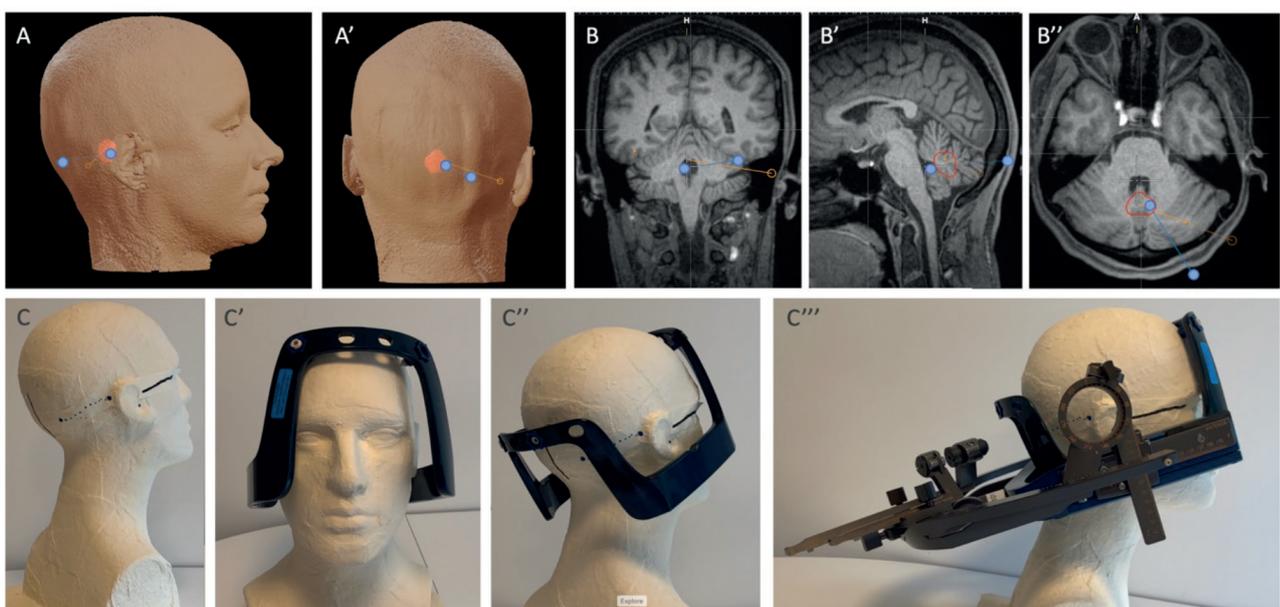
Example of a more medial entry and flatter trajectory that allow frame placement with little axial and sagittal rotation. A, A': using landmarks from 3D model of software; B, B', B'': using landmarks from raw MRI images to transfer target and entry (blue circles) on patient (C). Frame placement with little axial (C') and sagittal rotation (C''). C''': with arc system attached.
